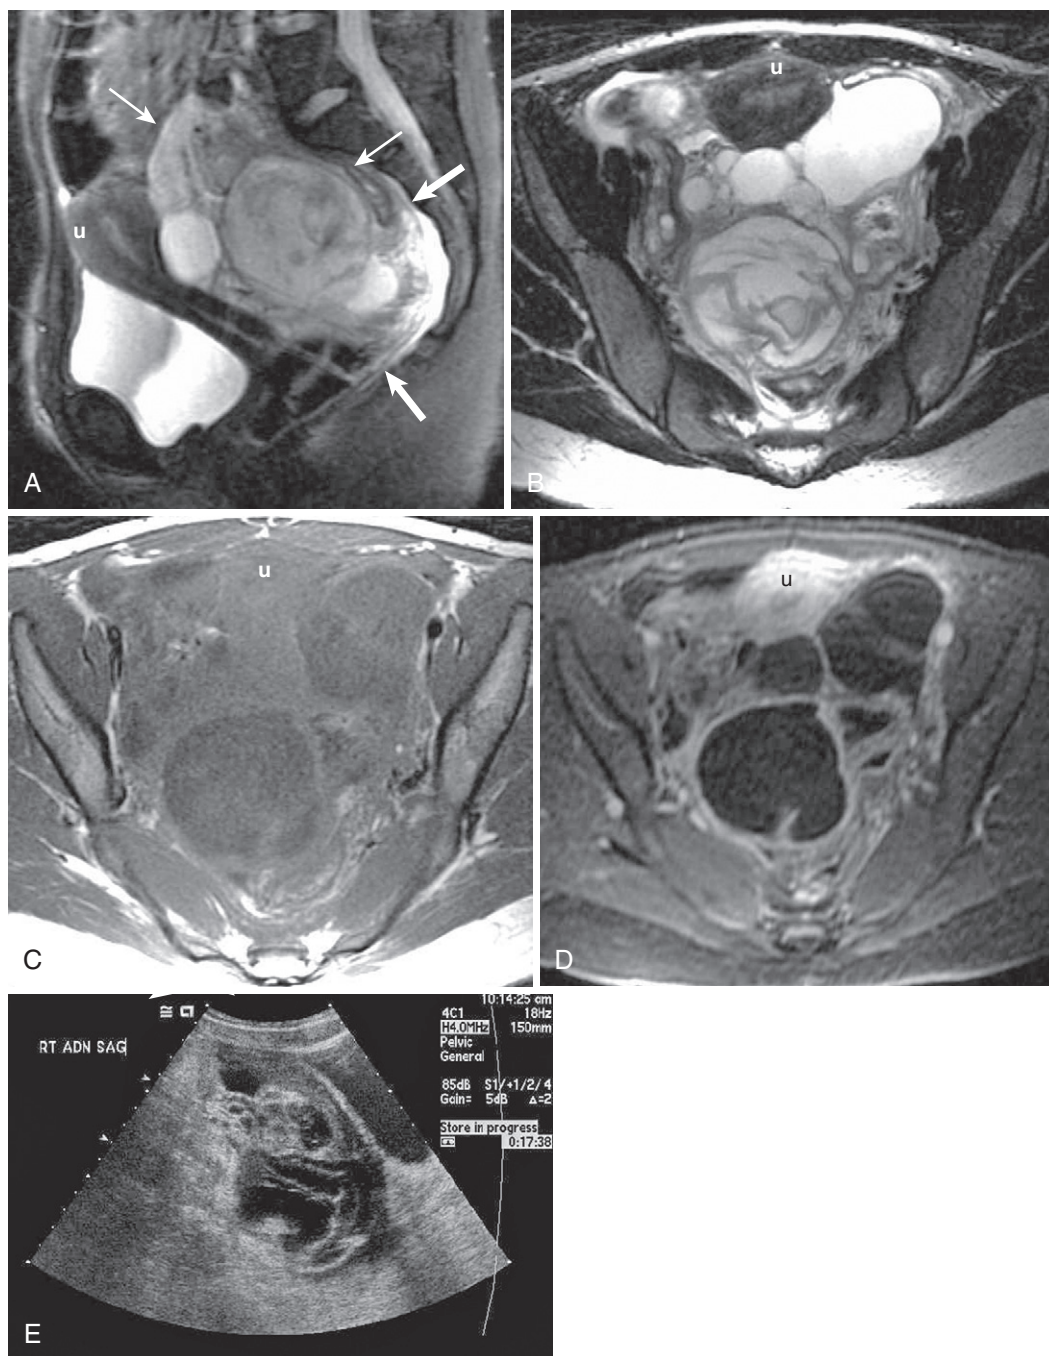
TOA. A, The sagittal T2-weighted fat-suppressed image demonstrates a complex cystic lesion (*thin arrows*) with surrounding edema (*thick arrows*) in the cul-de-sac displacing and compressing the uterus (u). The axial T2-weighted image (B) reveals the extent of the multiloculated inflammatory process, and the corresponding T1-weighted image (C) excludes hemorrhage. D, After gadolinium administration, the T1-weighted fat-suppressed image shows the degree of wall thickening and enhancement. E, An ultrasound performed immediately before the magnetic resonance imaging (MRI) corroborates the complexity of the collection.
